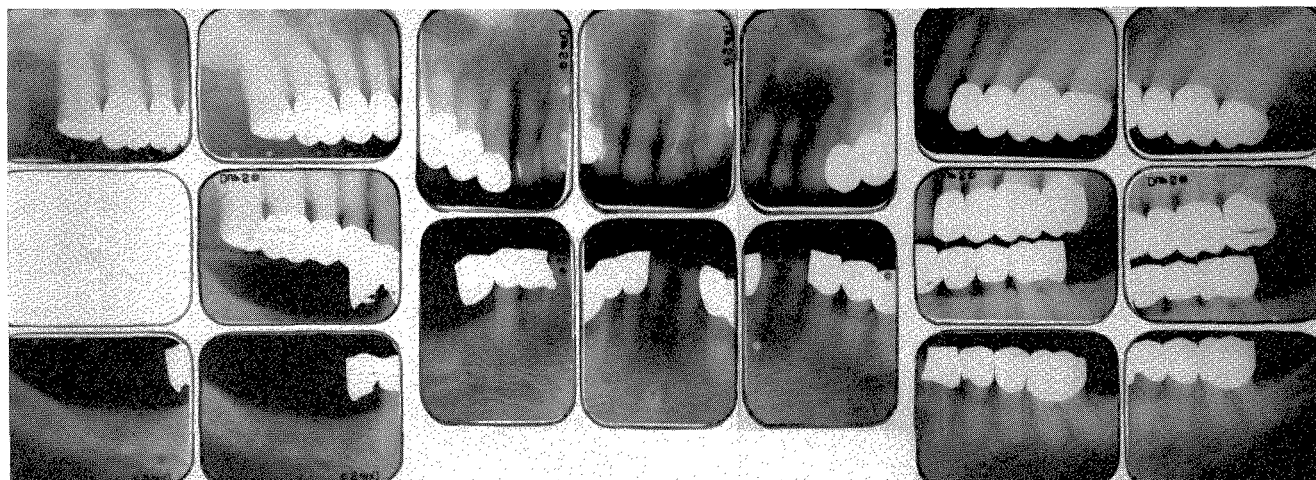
Roentgenograms taken in December, 1958. The lower right bicuspid root was removed, and the right lateral incisor was added to the splint. The lower left lateral incisor jacket was replaced by a veneer. Otherwise, the structures remained unchanged in the five years that passed since the case was completed.
